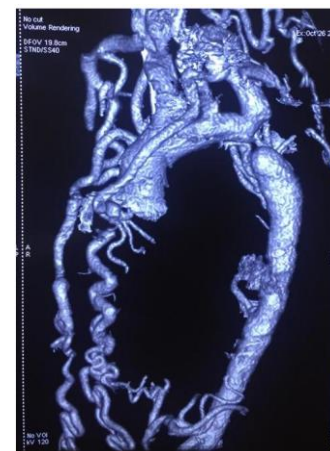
Preoperative, contrast-enhanced, 3-dimensional, computed tomography aortogram reveals interruption of the aortic arch beyond left subclavian artery (interrupted aortic arch, type A). Extensive collateral vessels to descending aorta are evident from the subclavian and intercostal arteries.
